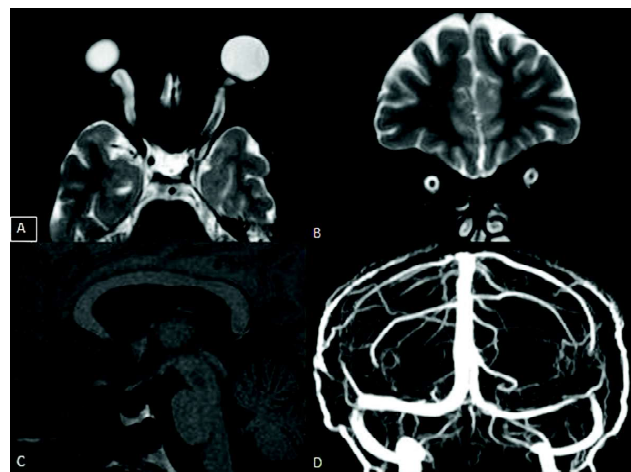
(A and B) are transverse and coronal T2-weighted fat saturated images shows marked distension of the perioptic subarachnoid space with flattening of posterior sclera. (C) Sagittal T1-W images shows flattening of the pituitary gland (D) MR venography shows no evidence of sinus thrombosis.
